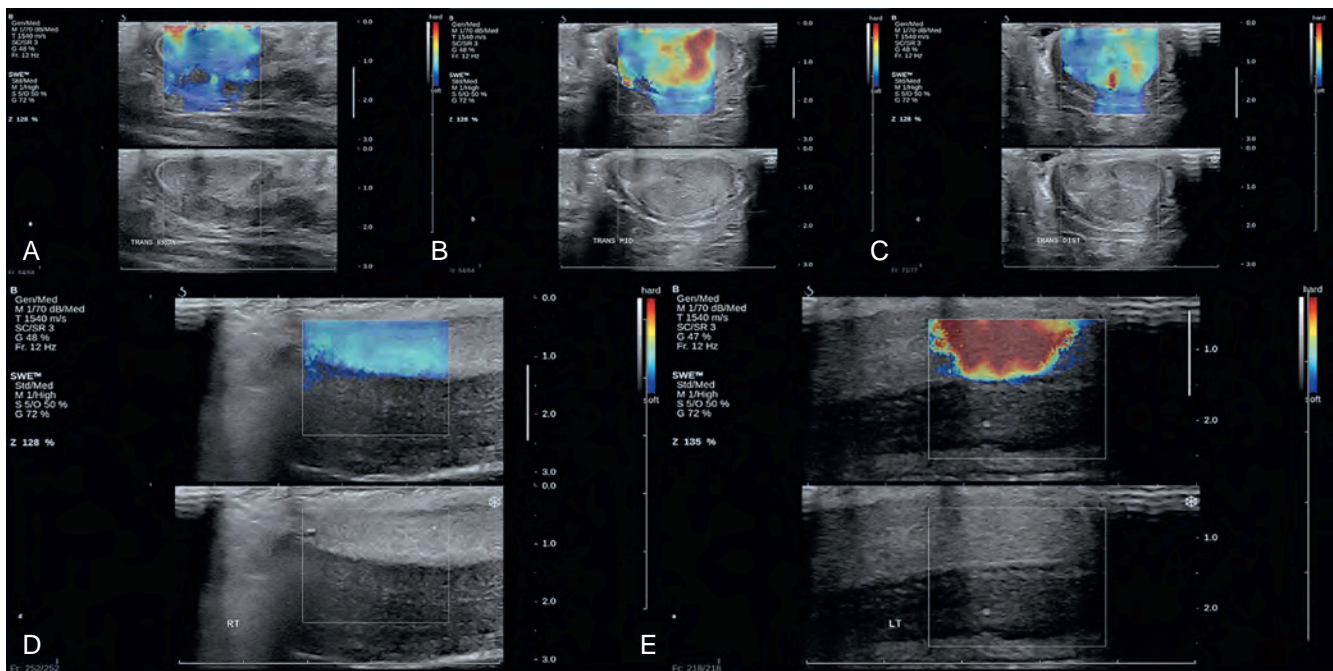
Sonoelastograms (scaled with red more firm and blue less firm) superimposed over transverse B-mode ultrasound images of the (A) proximal, (B) mid and (C) distal phallus. Sonoelastograms superimposed over parasagittal views of the (D) right and (E) left cavernosal bodies. (From Richards G, Goldenberg E, Pek H, Gilbert BR. Penile sonoelastography for the localization of a non-palpable, non-sonographically visualized lesion in a patient with penile curvature from Peyronie's disease. *J Sex Med* 2014;11:516–20.)
